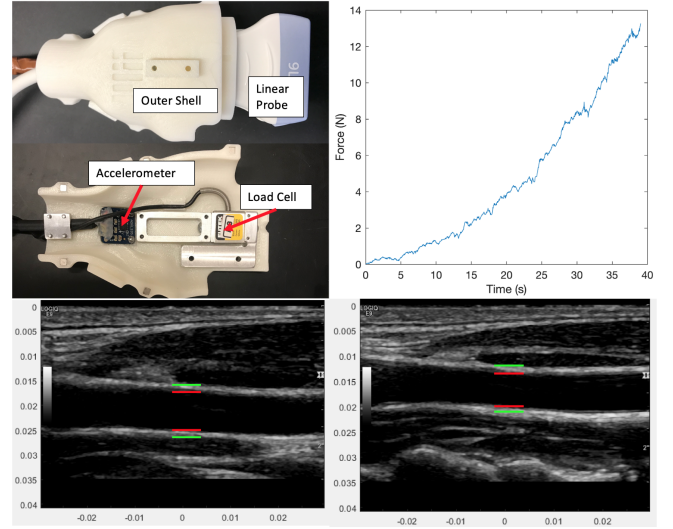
Force-coupled ultrasound setup (top left) and force sensed during force ramp (top right). Long-axis view of carotid artery in systole and under low force (bottom right) ($\approx 0N$) and high force (bottom left) ($\approx 12N$) (bottom). The annotations signify the carotid lumen in between the red horizontal lines and the anterior and posterior carotid vessel walls in between a red horizontal line and a green horizontal line
